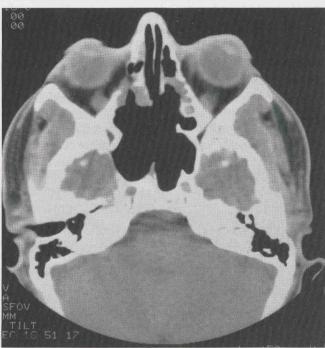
Post-operative CT scans of paranasal sinuses of patient shown in Figure 3 showing complete mucocele decompression (a: co-ronal; b: axial).
